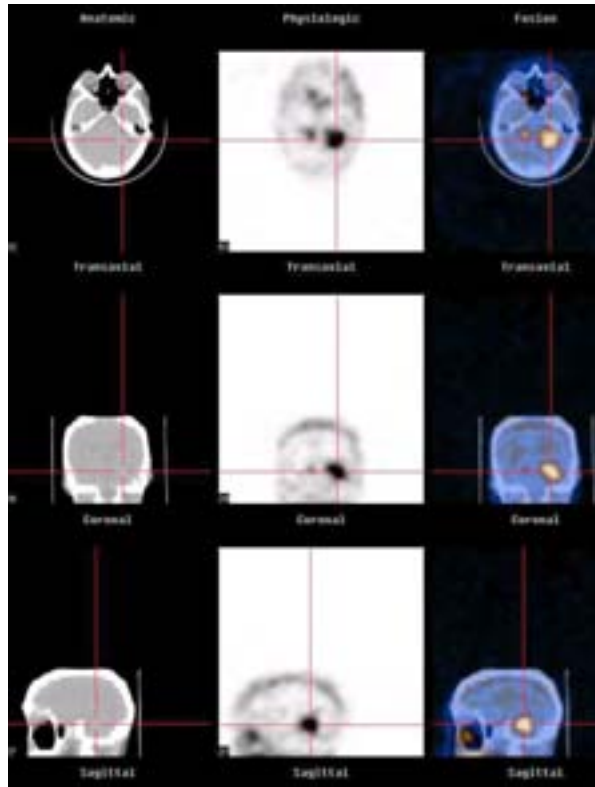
SPECT/CT performed after administration of ^{201}Tl -chloride in an HIV infected patient referred for differential diagnosis between primary lymphoma and cerebral toxoplasmosis. ^{201}Tl accumulation in the left hemi-cerebellum supports the diagnosis of primary lymphoma.
